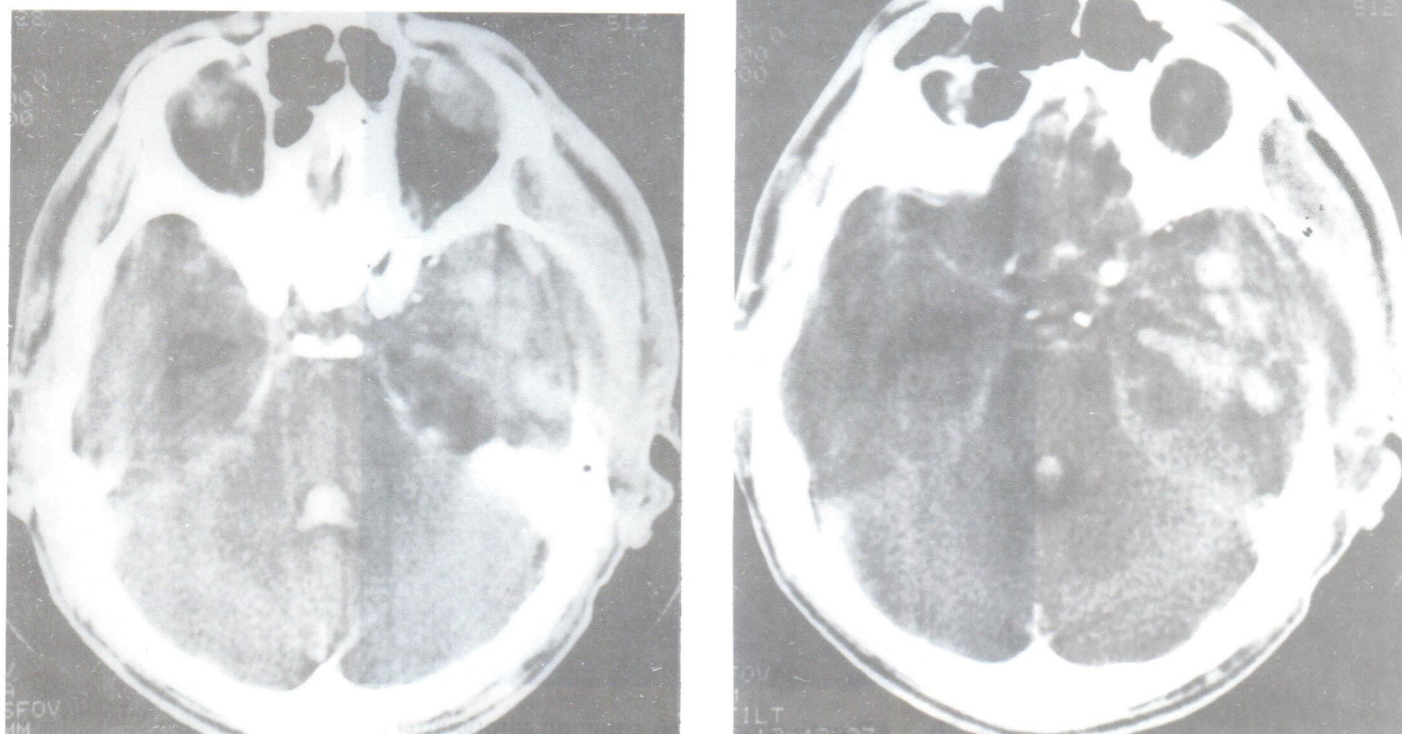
Post contrast CT scan of the brain showed a nodular enhancement at the mid anterior left temporal lobe.
